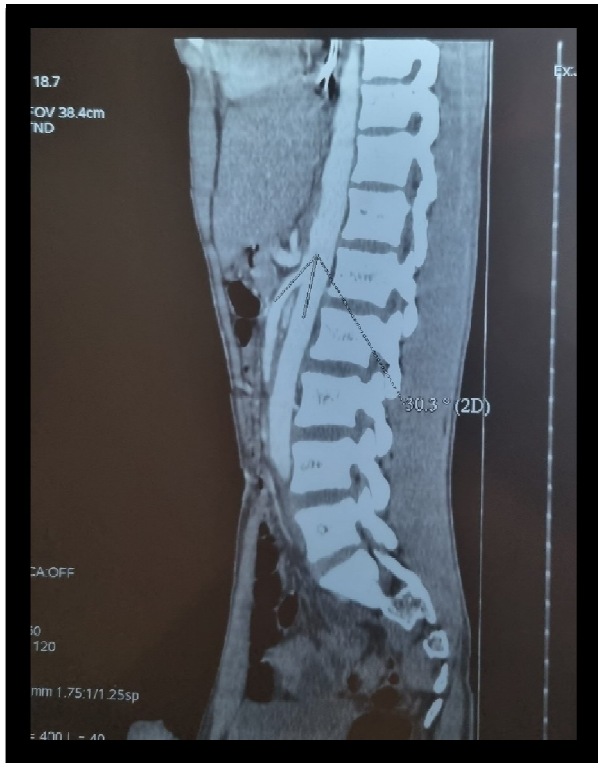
Sagittal section abdomino-pelvic CT scan before and after contrast material injection; A) angulation between abdominal aorta and superior mesenteric artery; B) measured at 30°, fulfilling the diagnostic criteria for NCA.
